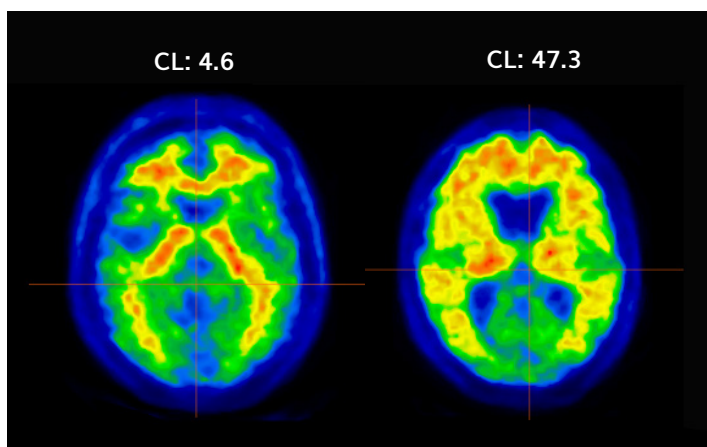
NeuroLF Amyloid PET images were acquired as part of clinical diagnostic routine and according to the standard protocol for [18F]flutemetamol, and uploaded in Hermes BRASS for automated quantification using template MRI (Courtesy of ProScan Imaging, Naples, Florida, the United States of America; <https://proscan.com/florida/>). Left image: CL: 4.6, Ratio (Z) SUVr: 0.53 (0.24); Right image: CL: 47.3, Ratio (Z) SUVr: 0.69 (2.60).
